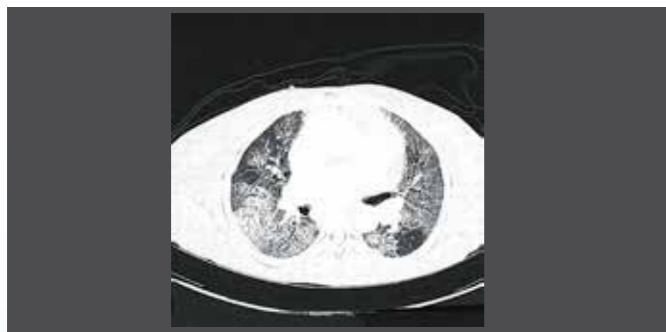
High-resolution computed tomography chest
